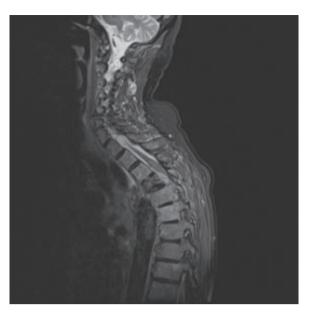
Spinal cord compression in mesothelioma. This 80-year-old patient with known malignant pleural mesothelioma presented with back pain, paraplegia, and urinary retention. (a) Magnetic resonance imaging of the spine shows tumour (short arrow) encasing the upper thoracic spinal cord resulting in severe canal stenosis and cord compression. (b) Malignant pleural disease is demonstrated by high signal intensity on the T2-weighted image.
